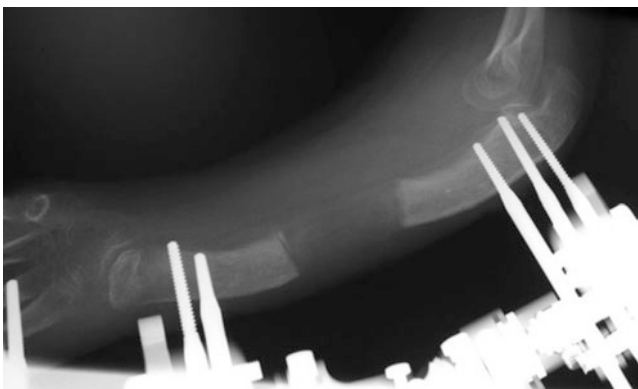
Radiographs well into the treatment show correction of alignment and lengthening
